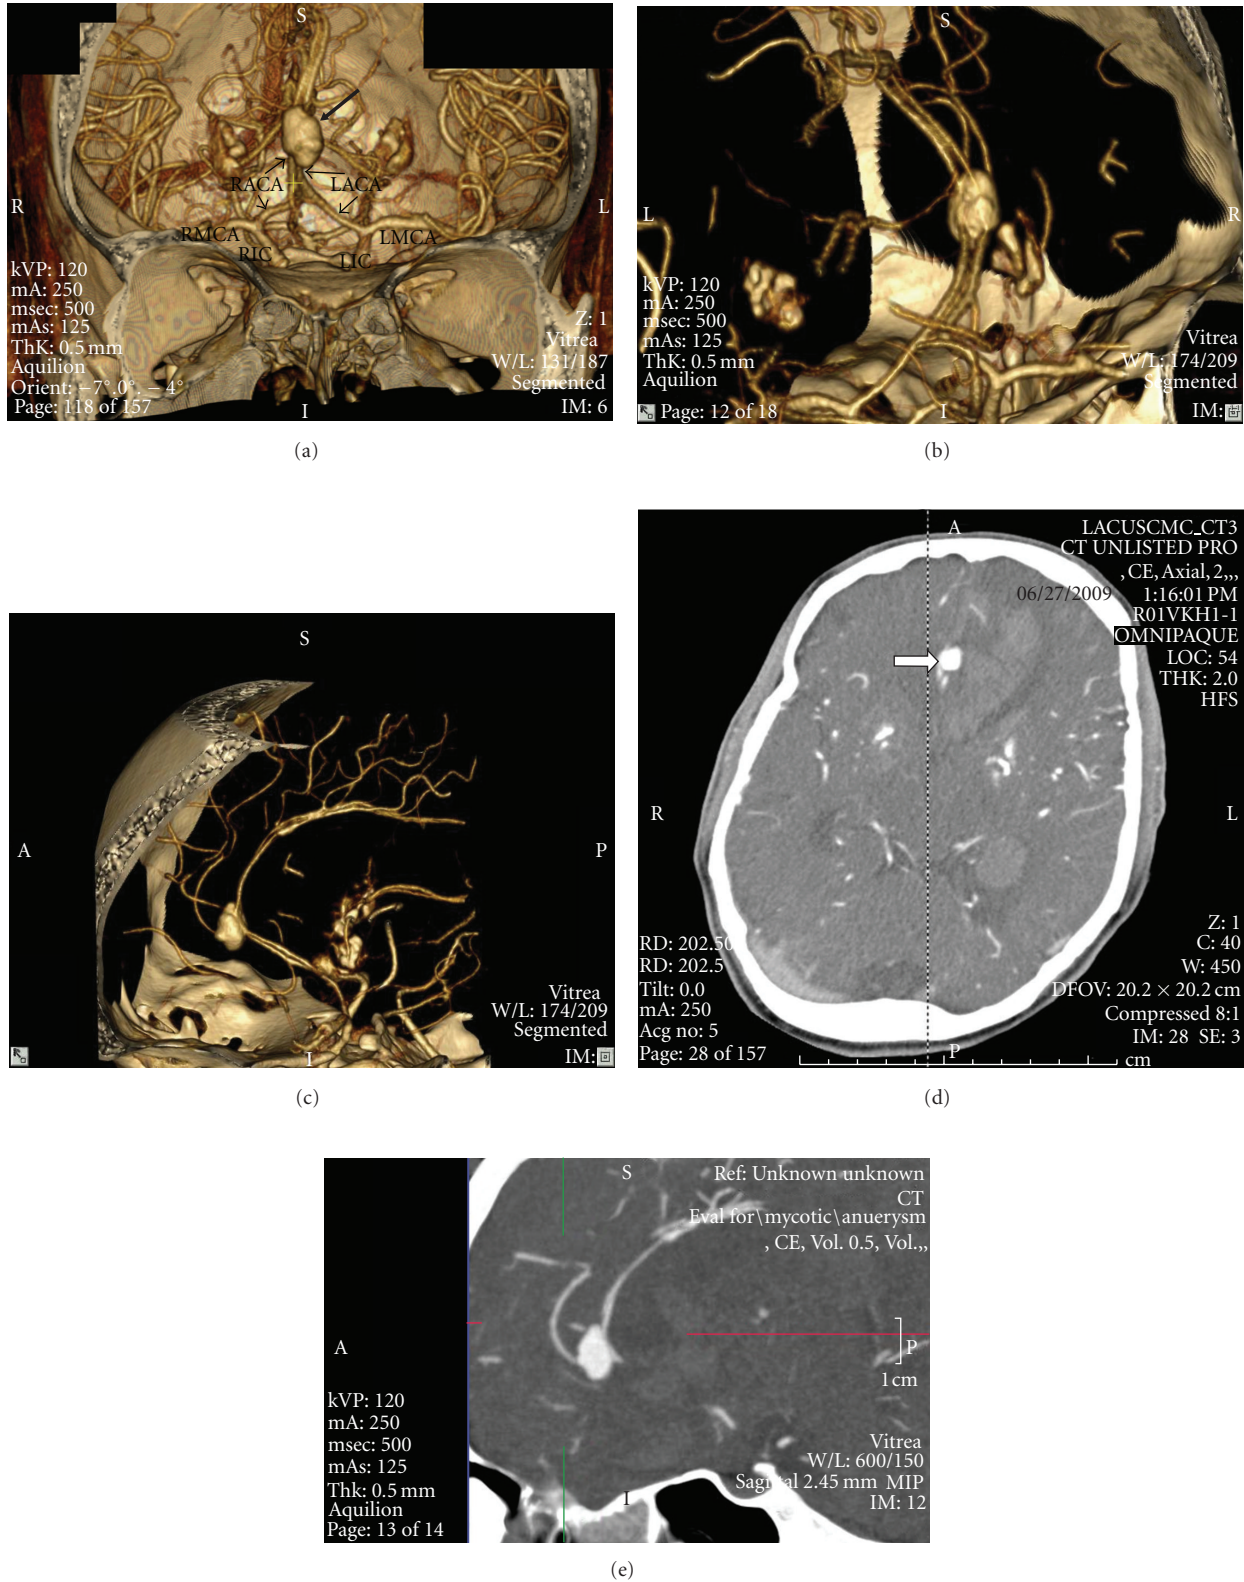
CT Cerebral angiogram showing a large fusiform aneurysm at the distal anterior cerebral artery (ACA). (a) Shaded Surface Display CT coronal view showing a large fusiform aneurysm at the distal segment of the ACA marked by the large arrow. Proximal ACA segments are marked by the smaller arrows. RIC: right internal carotid artery, LIC: left internal carotid artery, RMCA: right middle cerebral artery, LMCA-left middle cerebral artery, RACA and LACA are right and left anterior cerebral arteries, respectively. (b) Close-up coronal view of ACA mycotic aneurysm. (c) Additional sagittal view of mycotic aneurysm. (d) CT Angiogram axial view, an arrow marks the location of the ruptured aneurysm adjacent to a large hemorrhagic lesion. (e) CT Angiogram sagittal view demonstrating areas of intracerebral hemorrhage.
